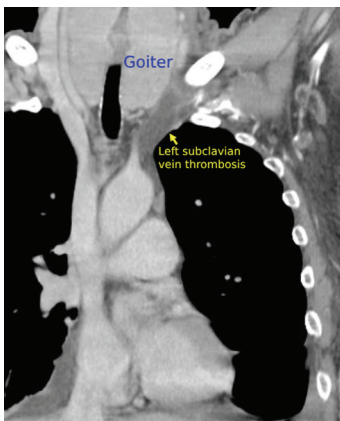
Coronal CT image of the left thoracic inlet. No direct compression of the left subclavian vein by the enlarged thyroid (goiter) was identified.
